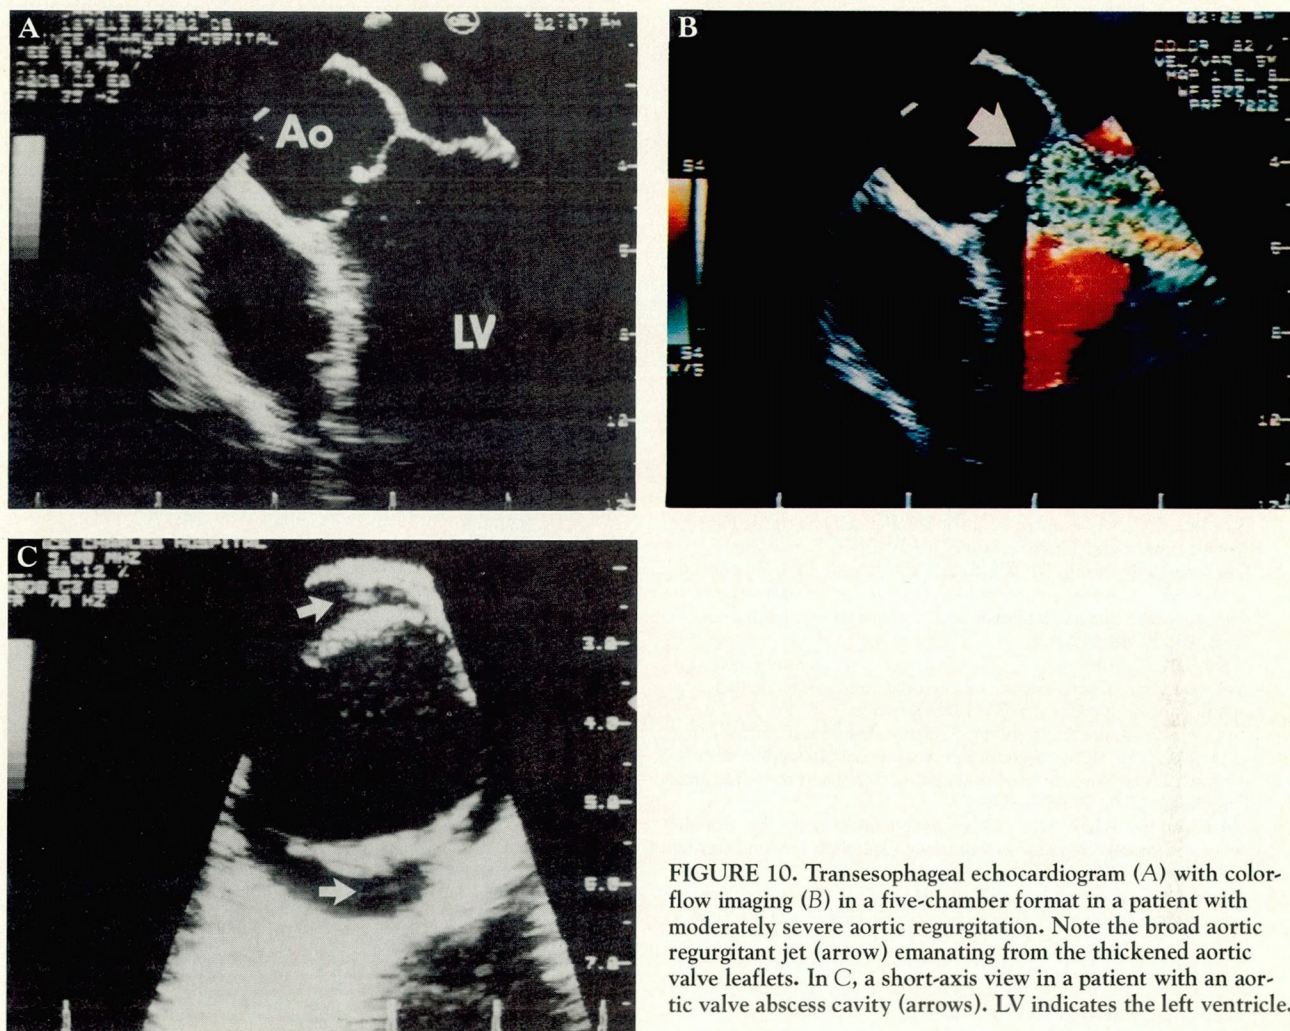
Transesophageal echocardiogram (A) with color-flow imaging (B) in a five-chamber format in a patient with moderately severe aortic regurgitation. Note the broad aortic regurgitant jet (arrow) emanating from the thickened aortic valve leaflets. In C, a short-axis view in a patient with an aortic valve abscess cavity (arrows). LV indicates the left ventricle.
